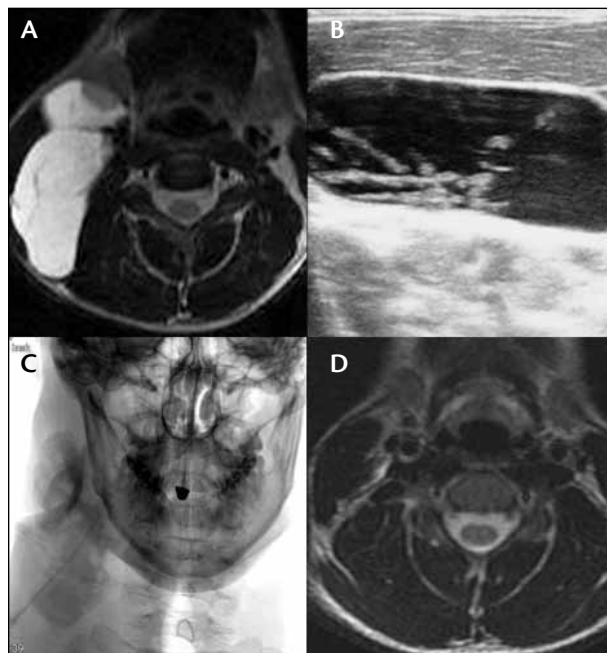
A 21-year-old man presented with a right neck mass. MRI (A) and ultrasound (B) revealed a large macrocystic lymphatic malformation. The lesion was percutaneously punctured under ultrasound guidance, and a 4-F catheter was placed. The lesion was treated with doxycycline (injection of opacified doxycycline) (C). A follow-up MRI 4 months after sclerotherapy demonstrated complete resolution of the lesion (D).
